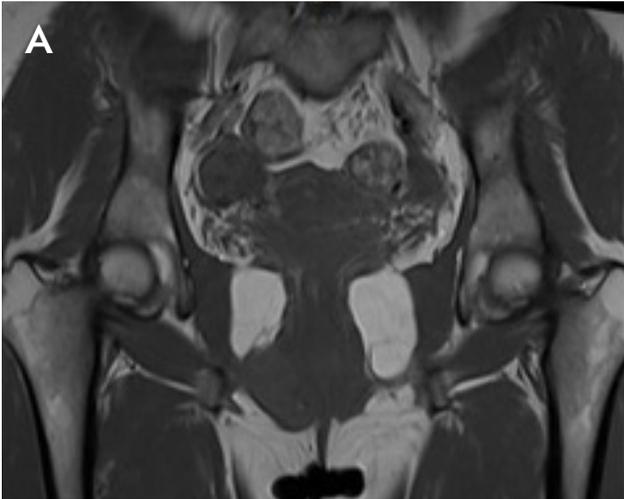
MRI. T1 Sequence in coronal section.
